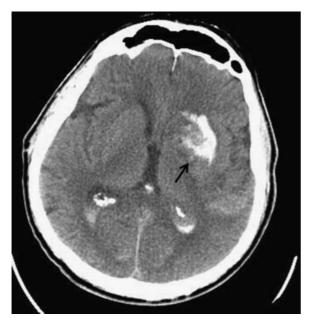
Axial noncontrast CT scan following thrombectomy for internal carotid artery occlusion and ischemic stroke. A "contrastoma" has appeared in the left thalamus due to extravasation of contrast material secondary to blood-brain barrier breakdown (*arrow*).
